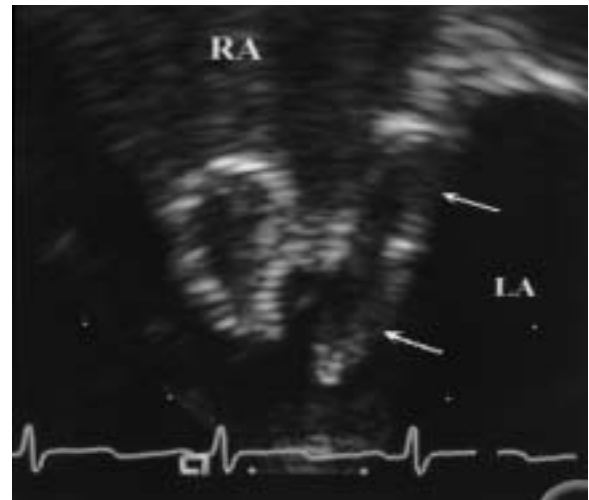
Transesophageal echocardiogram of an Amplatzer percutaneous closure device (arrows). LA = left atrium; RA = right atrium. Photograph courtesy of Naser M. Ammash, MD, Division of Cardiovascular Diseases, Mayo Clinic College of Medicine, Rochester, Minn.
